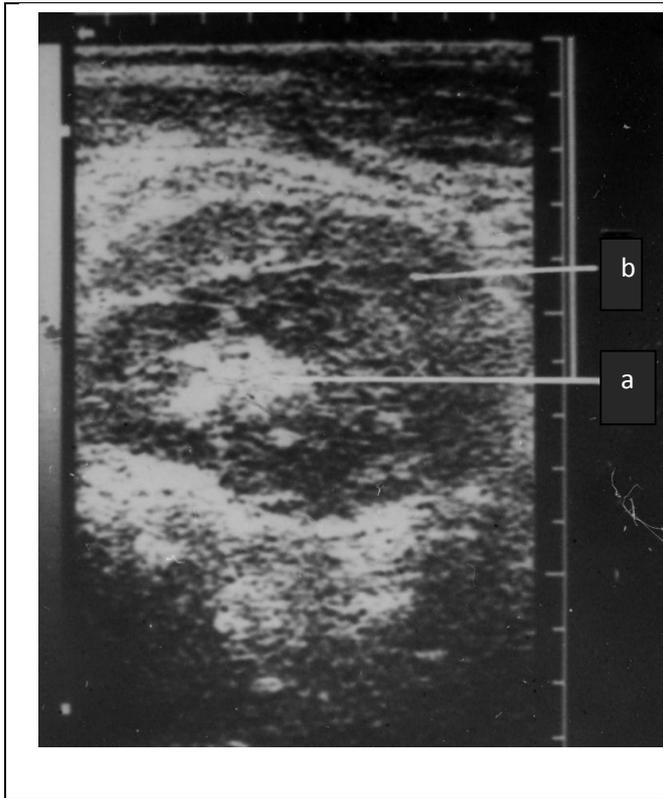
Sonogram of kidney.
